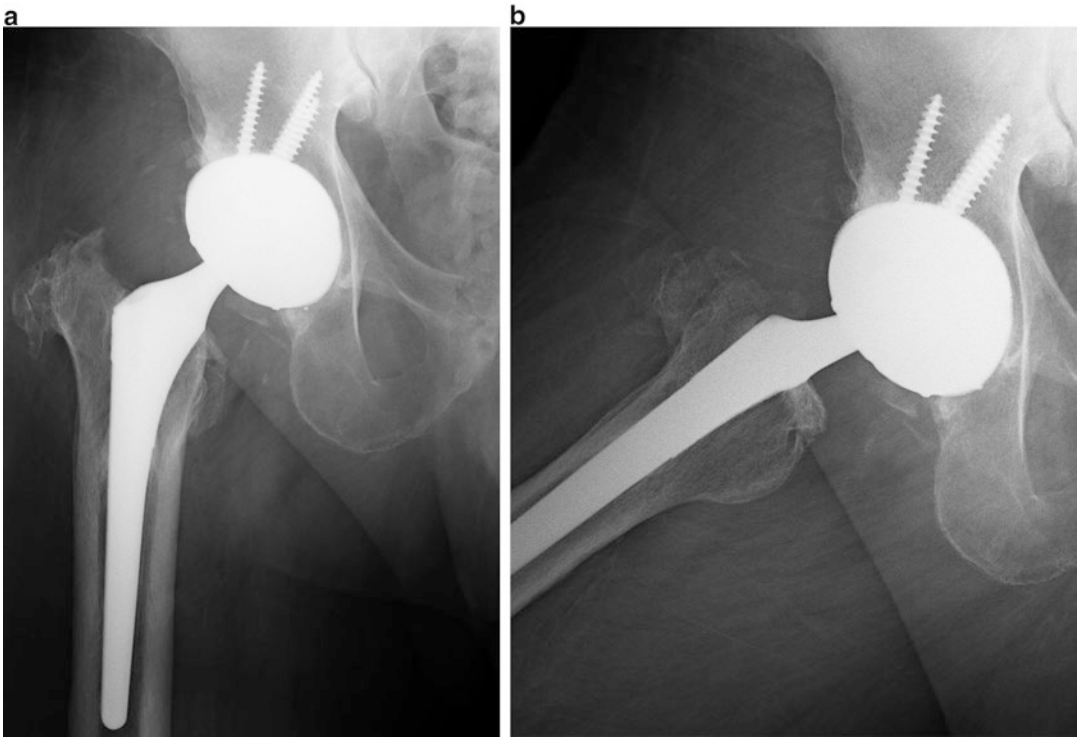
(a) AP radiograph, (b) frog leg radiographs of right total hip arthroplasty after removal of heterotopic bone
